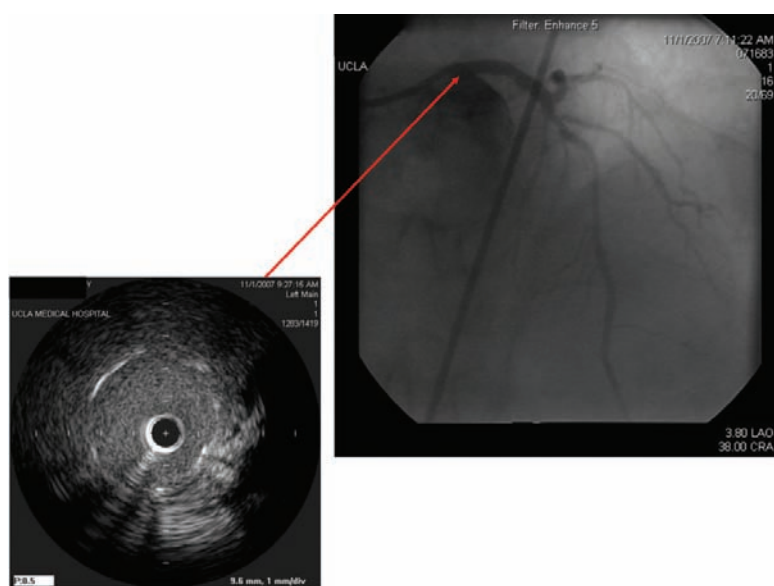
Final angiographic images demonstrate excellent angiographic results. Intravenous ultrasound demonstrates excellent stent apposition and confirms coverage of the ostial unprotected left main coronary artery with stent struts visible in the aorto-ostial junction.
